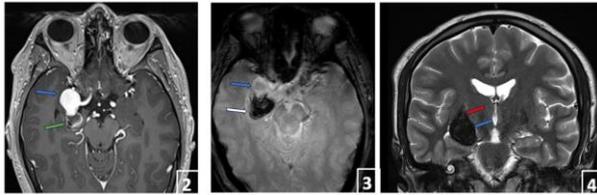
Axial T1-weighted enhanced brain MRI showing a prebifurcation right internal carotid aneurysm (blue arrow) and a posterior pseudo-aneurysmal sac partially thrombosed, compressing the optic tract (green arrow).
